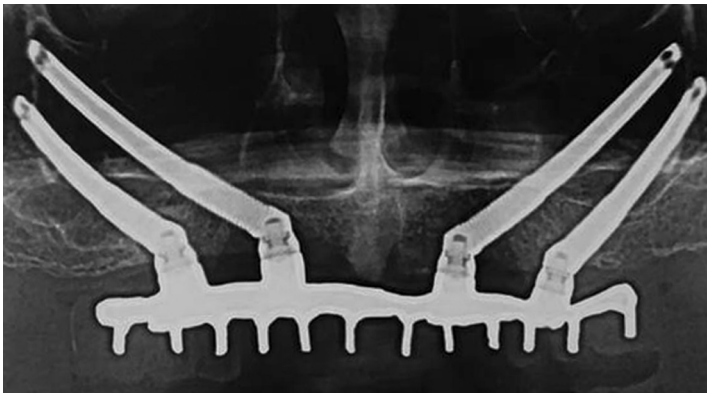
Panoramic radiograph at 3 years after loading in one of the patients with a severely atrophic maxilla randomly allocated to receive four immediately loaded zygomatic implants (Dr. Pistilli, Rome).
